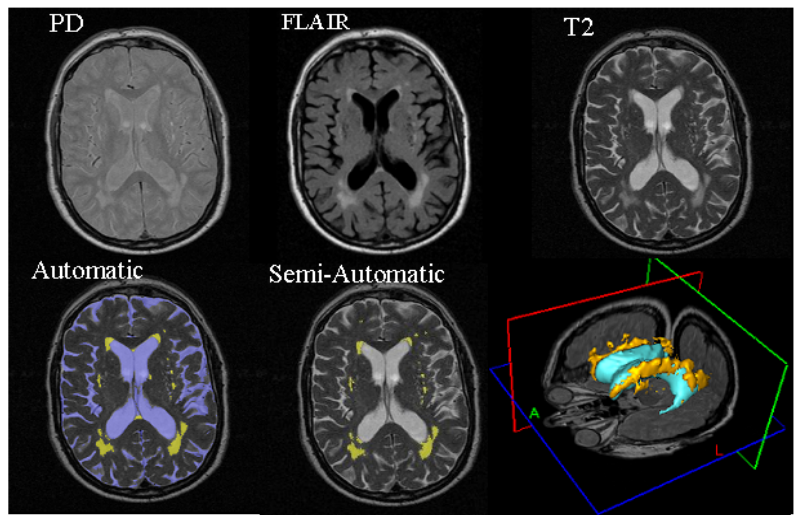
Top row: MR image of the same patient. Bottom-left: fully automatic segmentation of CSF (blue) and WML (yellow). Bottom-center: semi-automatic delineation of WML. Bottom right: 3D rendering of automatically delineated WML.
